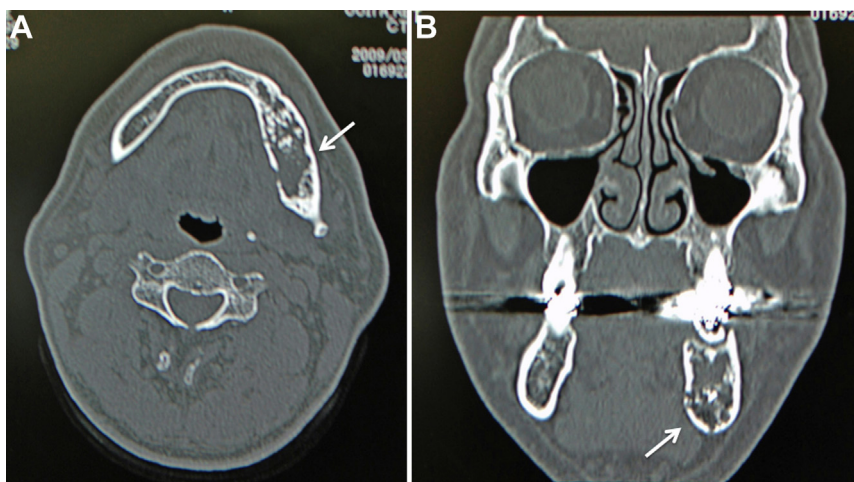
Computed tomography view. (A) Computerized tomography revealed a mixed radiolucent–radiopaque lesion in the left mandible and expansion and perforation of the mandible (arrow) (horizontal view). (B) Computerized tomography revealed a mixed radiolucent–radiopaque lesion in the left mandible and expansion and perforation of the mandible (arrow) (coronal view).
